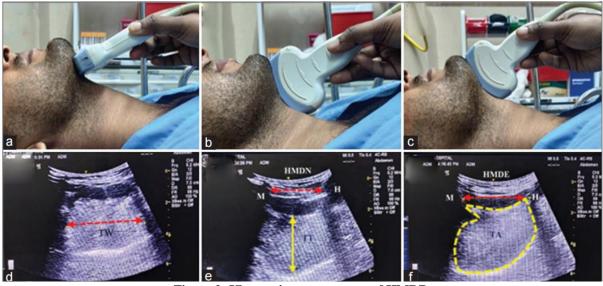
Ultrasonic measurement of HMDR
